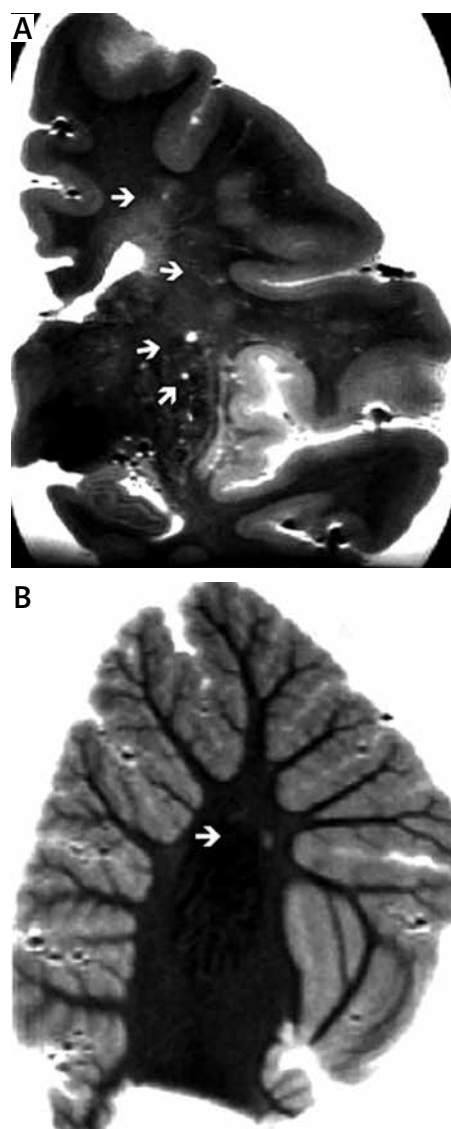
T2 MRI showing on a central coronal section in addition to diffuse white matter changes also several lacunar infarcts in the corona radiata and putamen (arrows) in a patient with vascular dementia (A). A lacunar infarct is also observed in the cerebellar white matter of the same patient (B).
